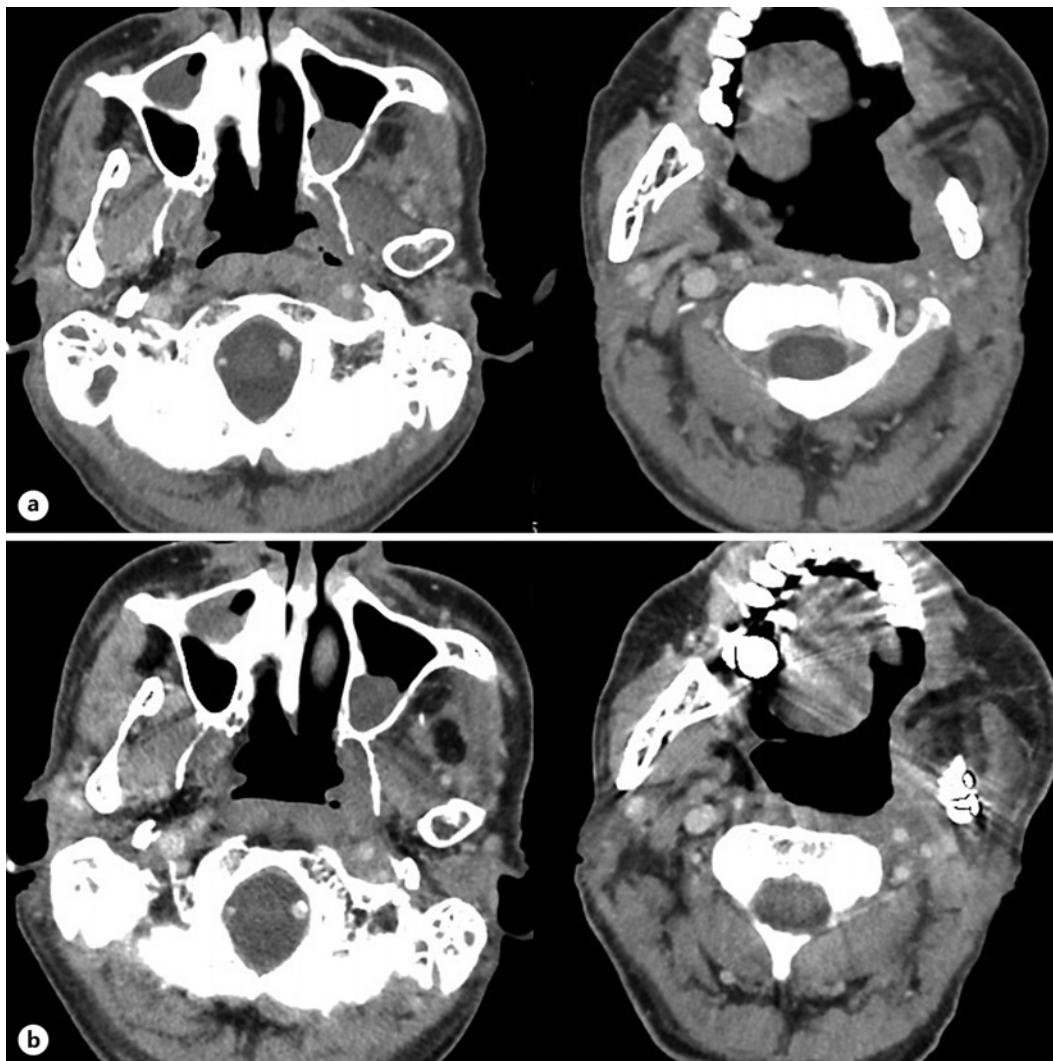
a Computed tomography (CT) images 2 months after the first dose of pembrolizumab. b CT scan images 1 year after the first dose of pembrolizumab.
